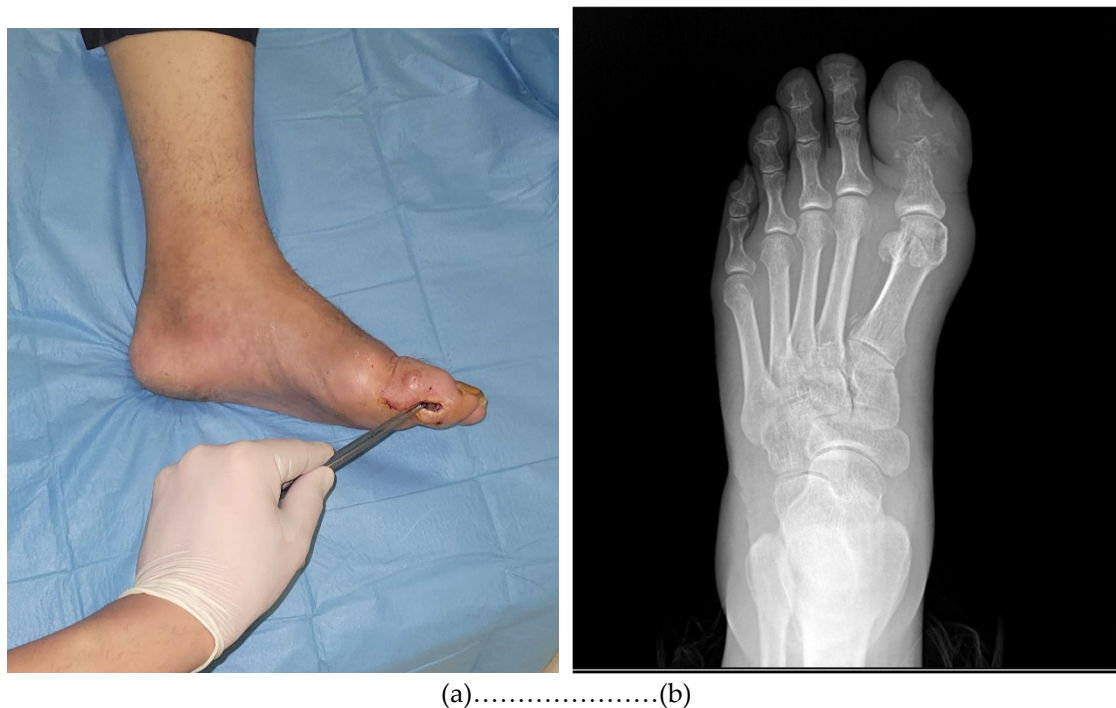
(a) Diabetic toe osteomyelitis with positive probe-to-bone test. (b): Same patient, X-ray image consistent with osteomyelitis. Cortical irregularities, osteolytic lesions, and soft tissue edema are observed at the level of the interphalangeal joints.
